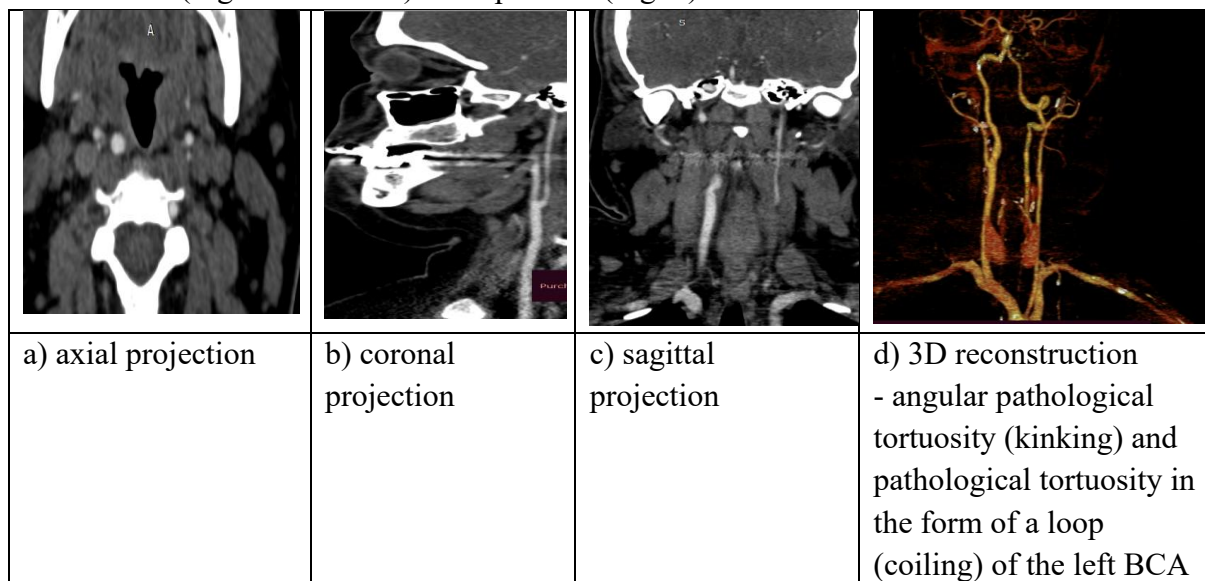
Female patient, 27 years old. Moyamoya disease. Preoperative CT angiography of the extracranial cerebral vessels. Hypoplasia of the left internal carotid artery.
